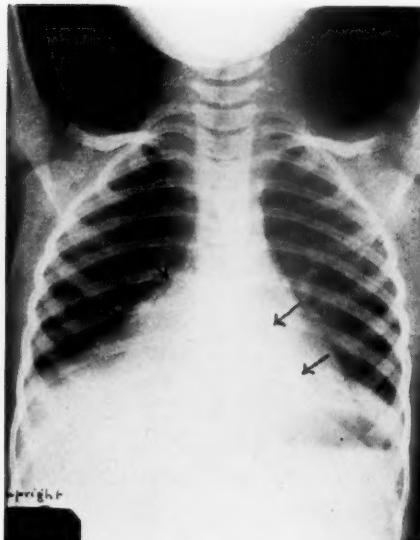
Radiograph showing bilateral triangular shadows in a four-year-old girl. Atelectasis has been present for at least a year.
